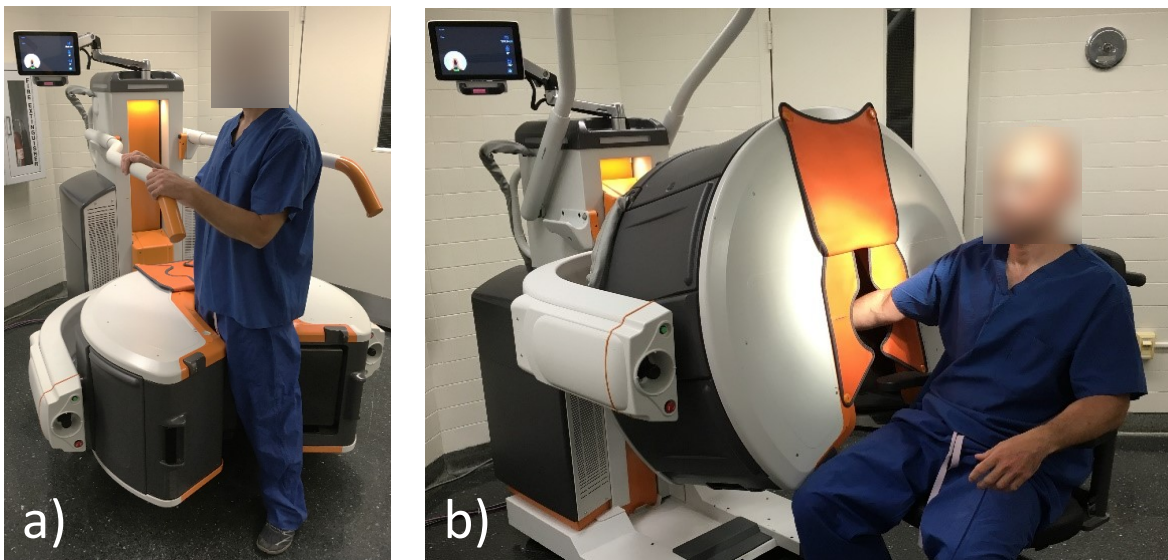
(A) Extremity CBCT in configuration for weight-bearing imaging (B) Extremity CBCT in unloaded configuration for imaging lower or upper extremity
